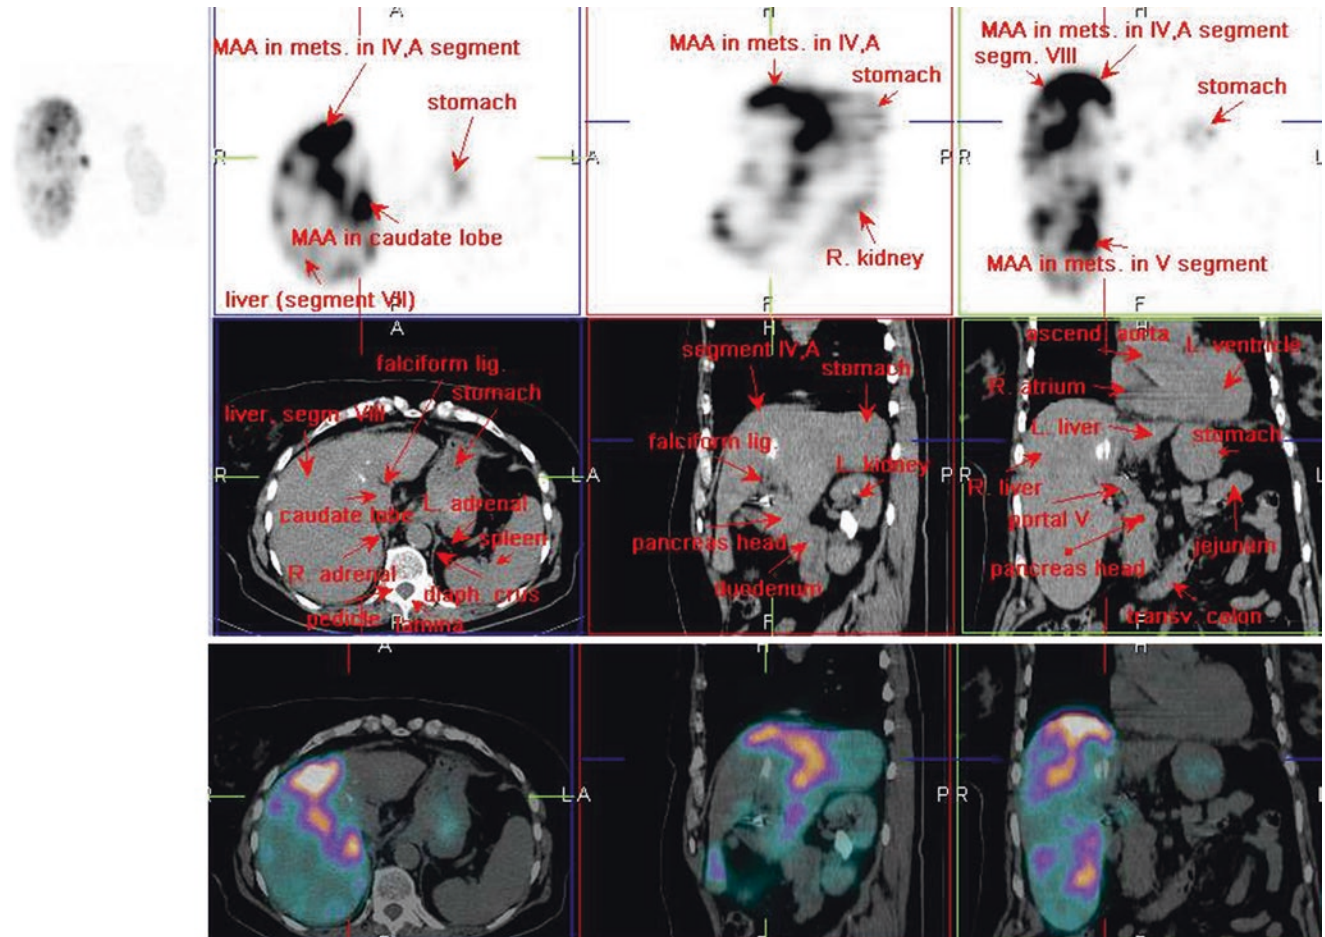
^{99m}Tc -MAA SPECT/CT
